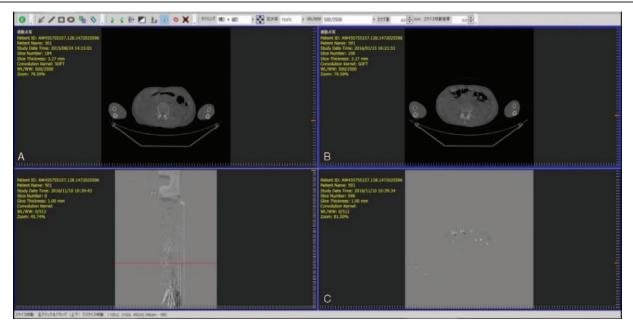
Screenshots of the image viewer for the observer study. A: initial CT, B: follow up CT, C: temporal subtraction image is displayed. CT = computed tomography.
